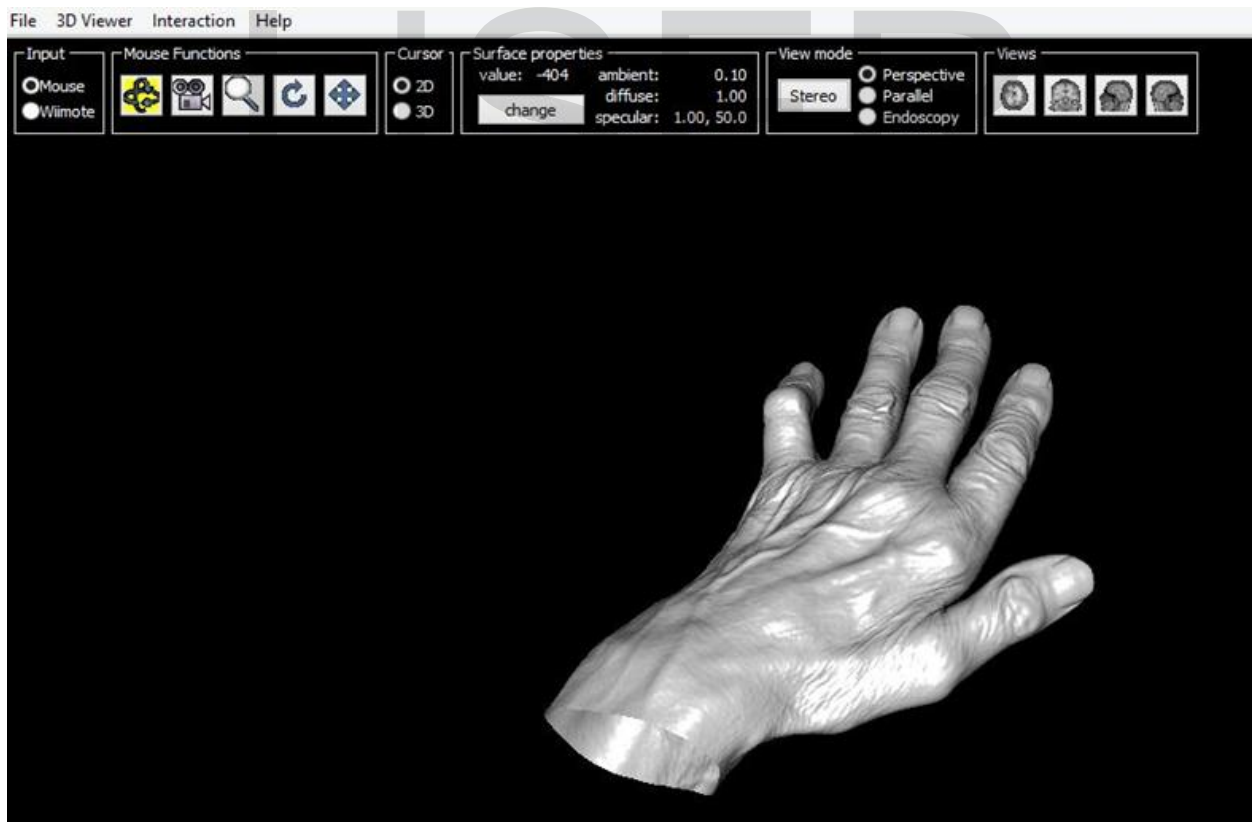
Reconstructed 3-D from hand CT with MITO.
